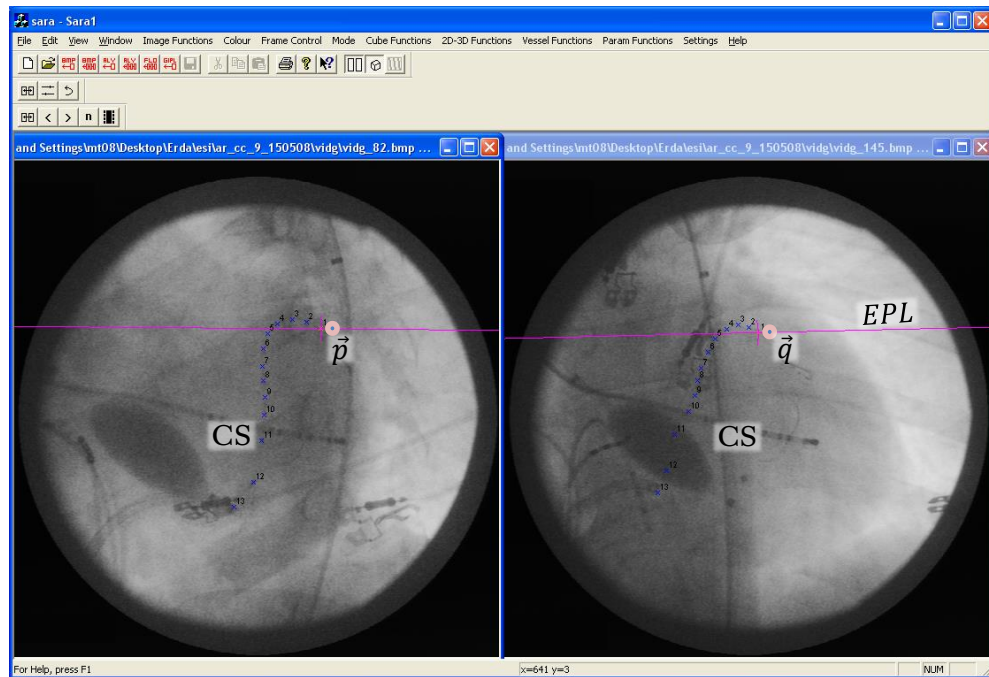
Screen shot of the software titled Sara showing X-ray LAO 30° and PA views of a patient's heart. Epipolar reconstruction is demonstrated with a with coronary sinus (CS) catheter inserted into the CS and into the great cardiac vein branch (GCV). A point \vec{p} from the left view generates an epipolar line (EPL, magenta) in the right view containing its corresponding point \vec{q} ; their back-projections reconstruct the point in 3D. Points along entire CS catheter can be reconstructed in 3D in this way.
